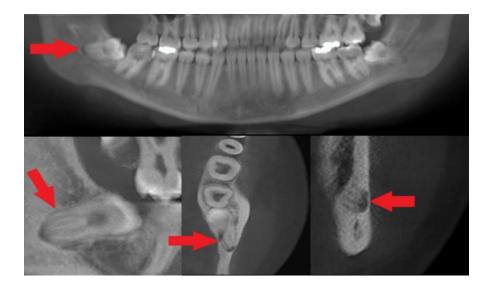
Multiplanar views of CBCT (Panoramic, sagittal, axial, coronal) show a juxta-apical radiolucency image (arrow), which appears as a well-circumscribed radiolucent area located laterally to the roots and continuously with the root apex of the third molar on the right side (Sinem, 2021).
